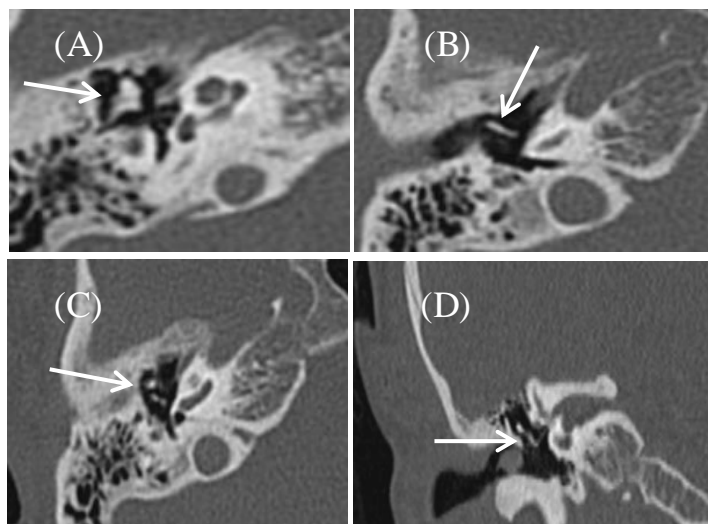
High-resolution CT scan of normal ossicles.
